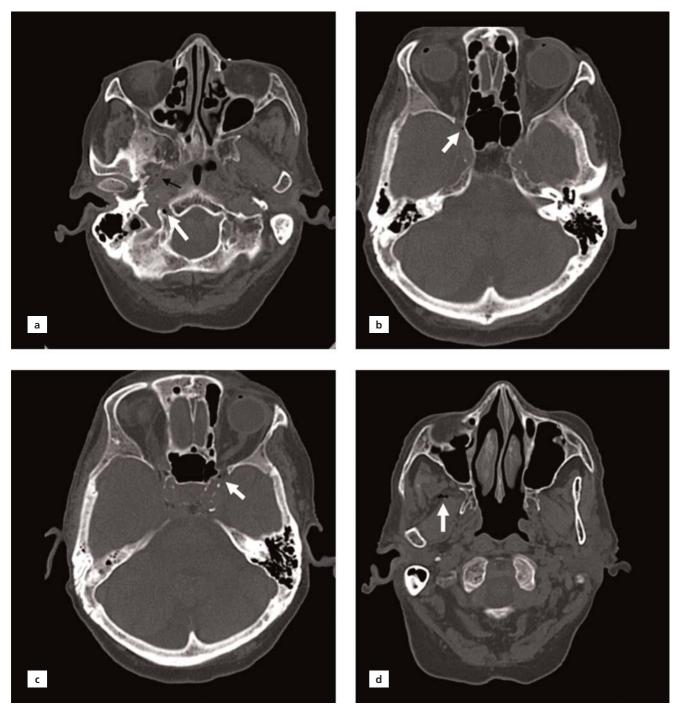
Bone window images of nonenhanced cranial CT. (a) Air bubbles in the venous plexus of the right hypoglossal canal (white arrow) and in the right pterygoid venous plexus (black arrow); (b) air bubble in the right ophtalmic vein (white arrow); (c) air bubble in the left ophtalmic vein (white arrow); (d) air bubbles in the right pterygoid venous plexus (white arrow).
